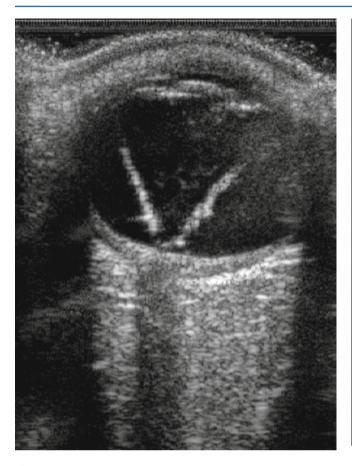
An ultrasound of a hypotonous eye with a total funnel retinal detachment from trauma
